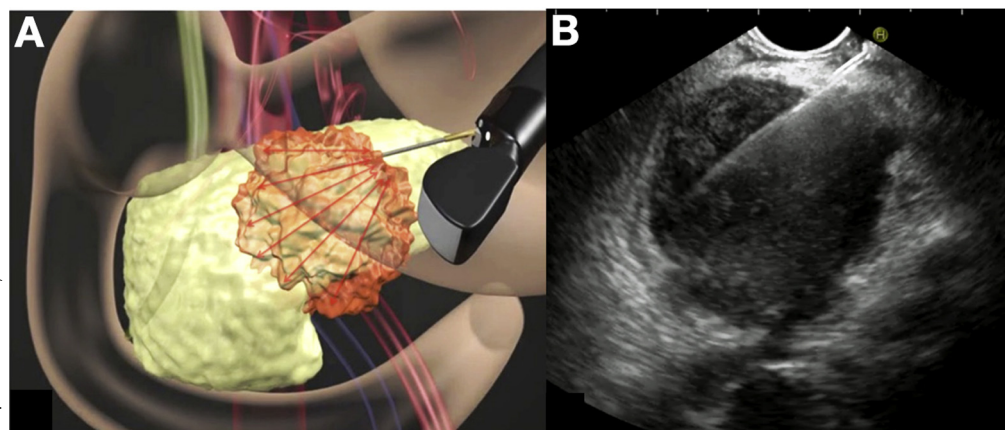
A, Oscillations of the puncture needle inside the lesion ("fanning technique"). B, Solid heterogeneous pancreatic lesion and ultrasound-guided fine needle aspiration biopsy.
